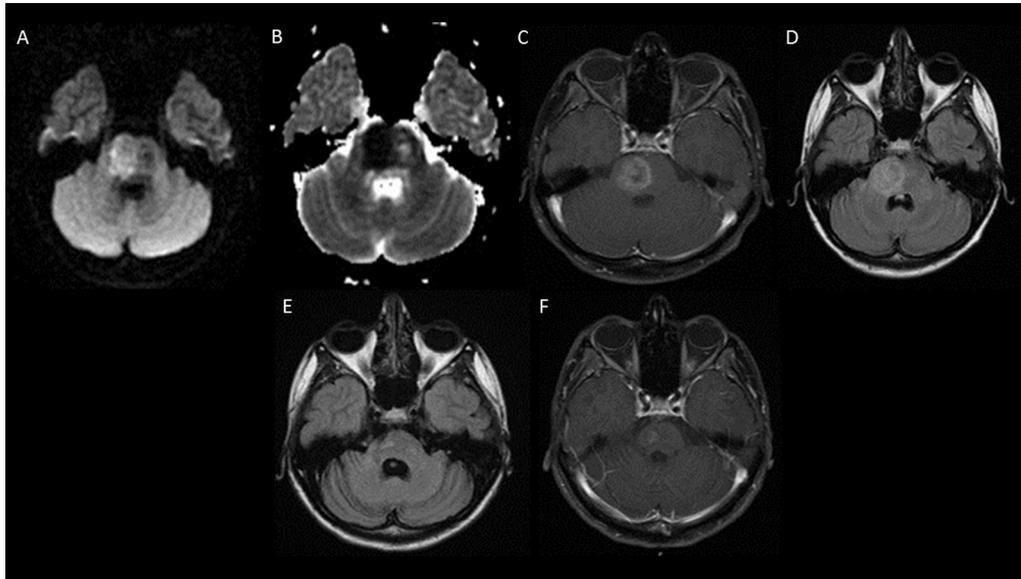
Magnetic resonance imaging (MRI) findings. MRI at diagnosis reveals a mass-like lesion in the pons with reduced diffusivity on diffusion-weighted imaging and apparent diffusion coefficient sequences (A and B) with heterogeneous enhancement postgadolinium (C) and mass-like appearance on fluid-attenuated inversion recovery (FLAIR) sequence (D). Three years postdiagnosis the MRI shows near resolution of the lesion on FLAIR and post gadolinium sequences (E and F).
